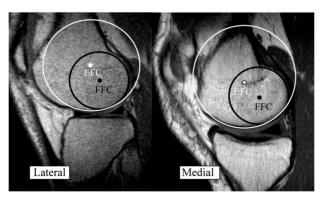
Sagittal MRI images of the lateral and medial tibiofemoral joints showing the posterior (Flexion Facet Centers-FFC) and anterior (Extension Facet Centers-EFC) circular arcs of the femoral condyles¹
